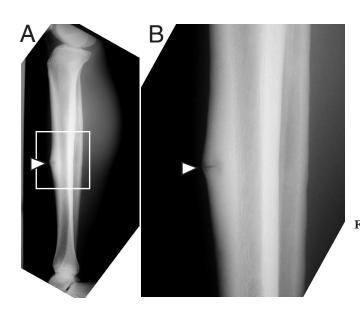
Lateral radiograph of anterior mid-tibia stress fracture (A). High magnification photograph clearly shows site of typical stress fracture with V- or wedge-shaped defect in the cortex of the anterior midtibia (bone umbauzone) (B, arrowhead).
